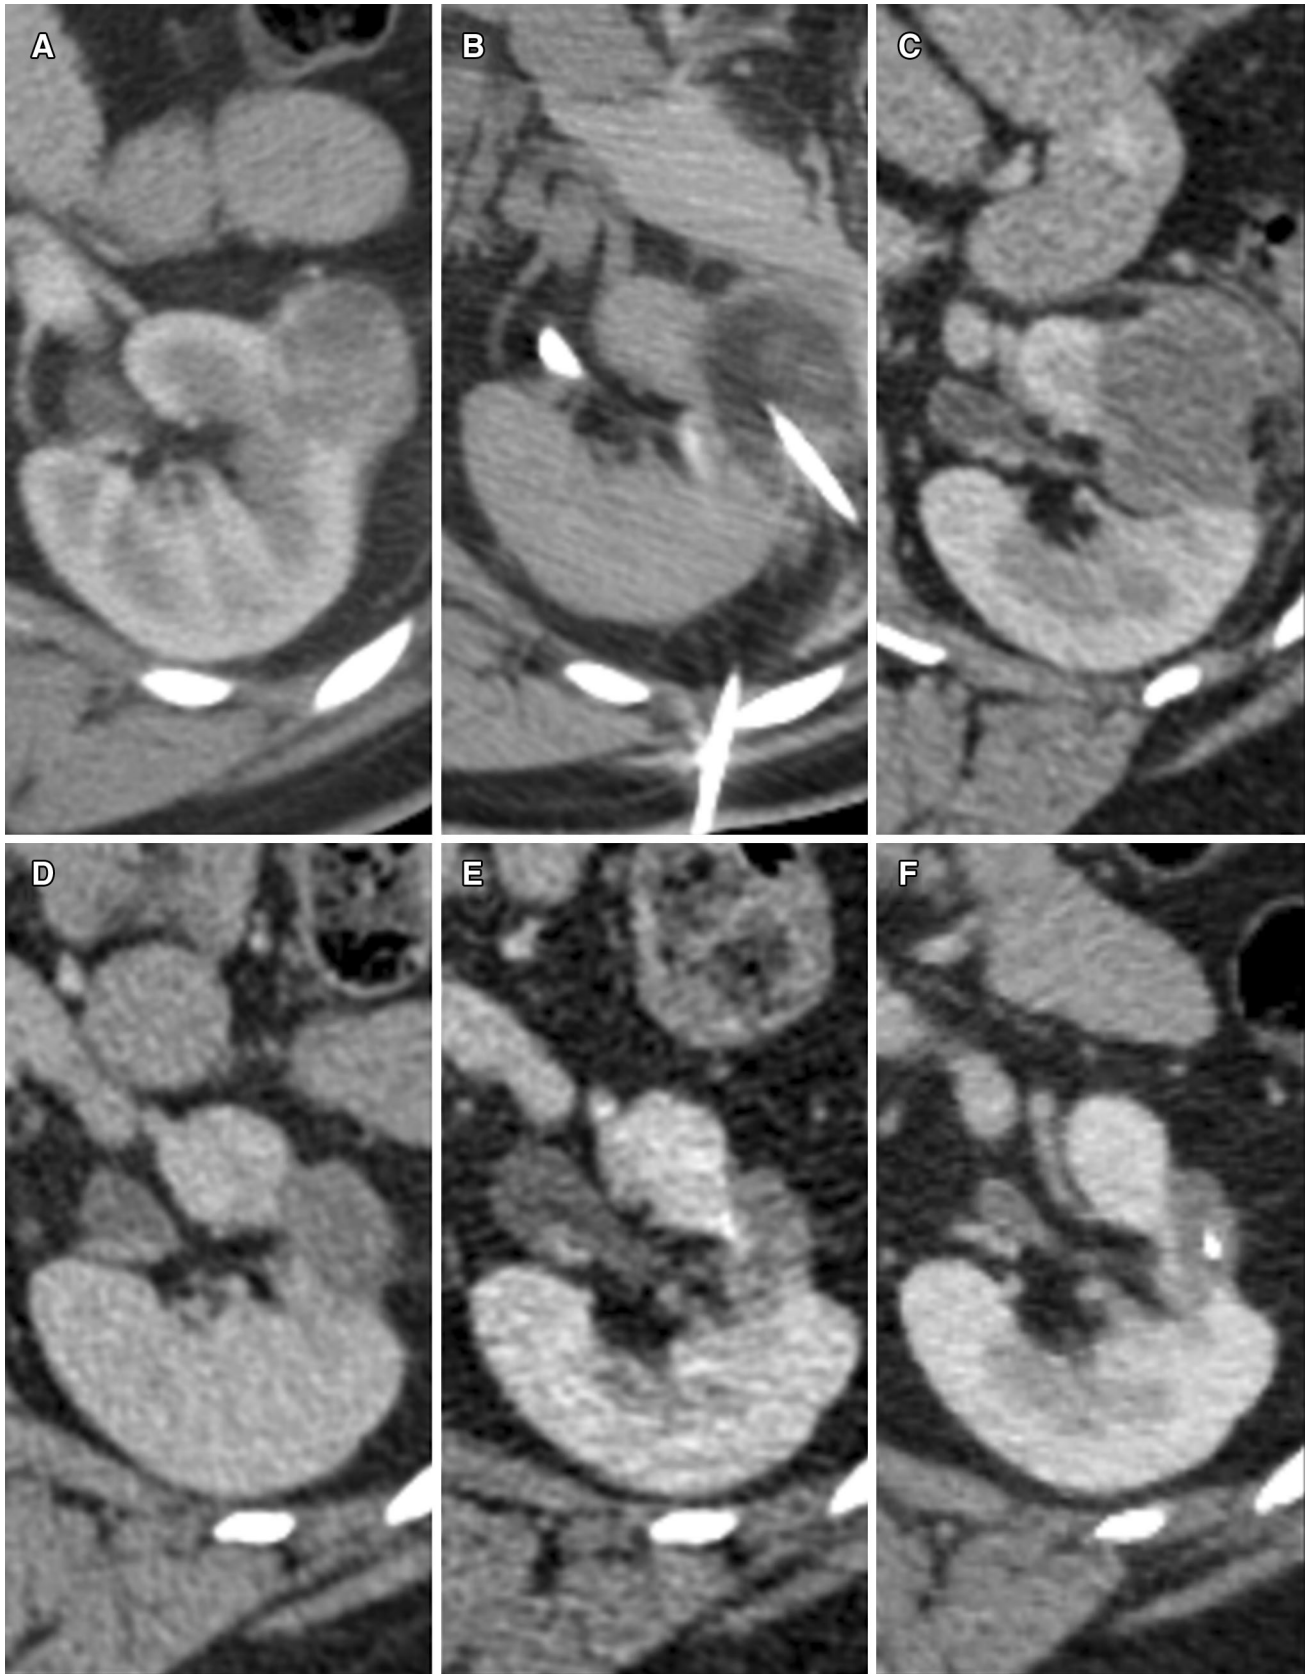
A 30-mm exophytic left anterior interpolar RCC. B ▶ Intra-procedural CT demonstrating an iceball around a cryoprobe. Note the bowel has been displaced by hydrodissection. C 2 weeks post-CRA demonstrating typical post-ablation appearance with complete devascularisation of the tumor. A crescent of high attenuation is seen at the anterior aspect which demonstrates a typical marginal rind seen with cryoablation. D 1 year post-CRA showing an 18-mm involuted devascularised ablation zone. E 3 years post-CRA demonstrating involuted scar tissue with no enhancing nodule. F 5 years post-CRA the ablation zone remains involuted with a central fleck of calcification.
